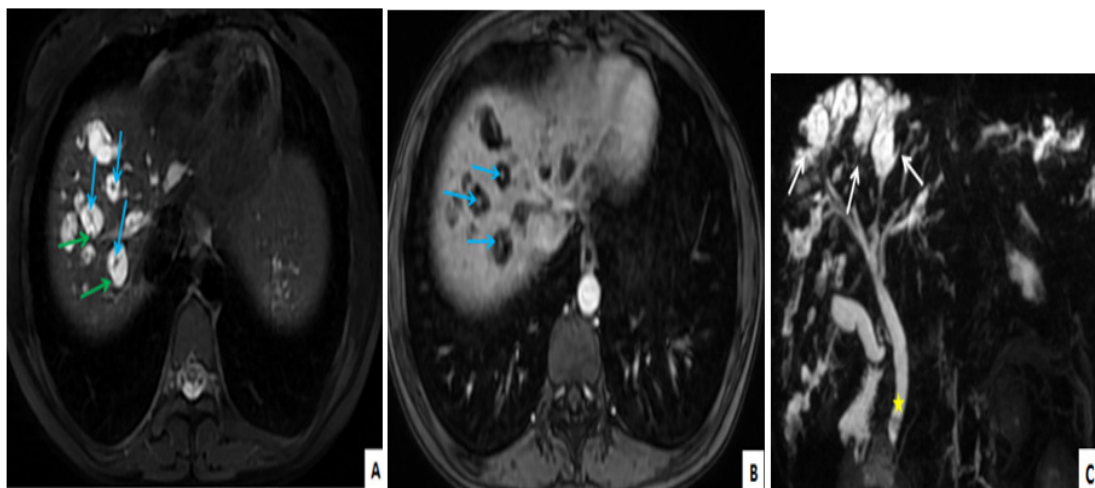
Liver MRI on T2 weighted images with fat saturation (A) showing large diffuse cystic ectasias of the intrahepatic bile ducts (green arrow) centred by branches of portal vein (blue arrow) enhanced on T1 sequence with portal injection (B) This is the central dot sign. MR cholangiography sequence (C) in the coronal plane showing biliary ectasia (white arrow) with gallstones of the main bile duct (star).
